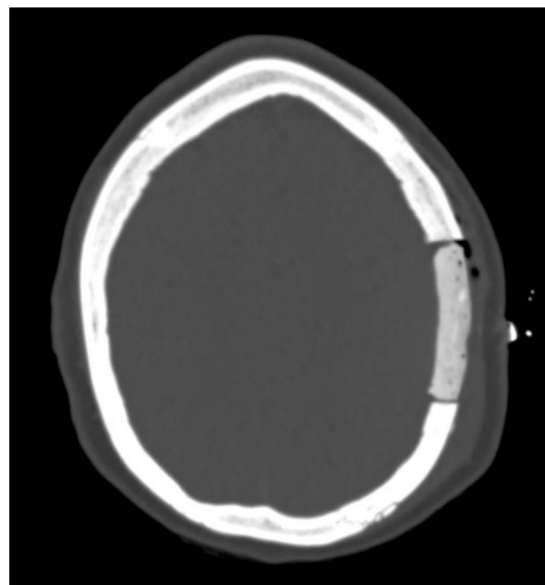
Sagittal CT scan (post-operative) showing proper placement of cranioplasty material (arrow).
